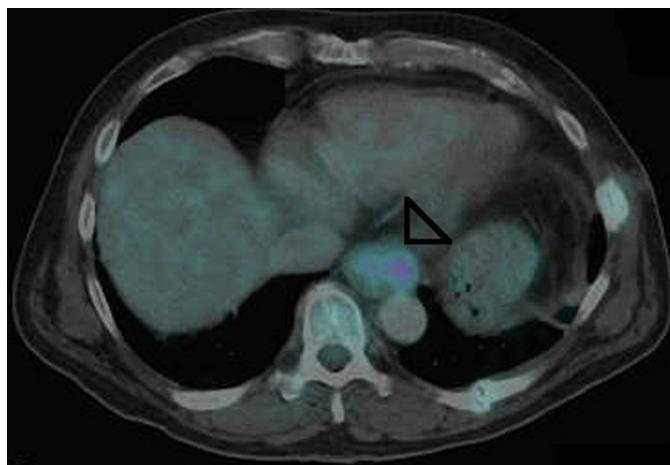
FDG-F-18 PET/CT scan showed an abnormally increased FDG uptake (arrow-head) at the level of the lesion described above.
